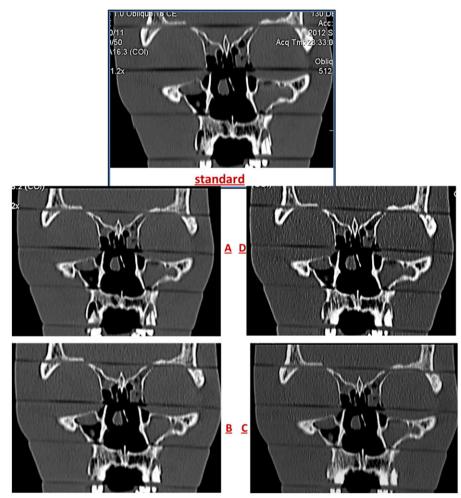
Coronal sections of bone window scanned at levels of maxillary sinus revealed the variations in image quality (image noise) of different MDCT protocols: standard multidetector CT (MDCT) protocol (Standard), (A) Protocol VII, (B) Protocol VIII, (C) Protocol IX and (D) Protocol X.
